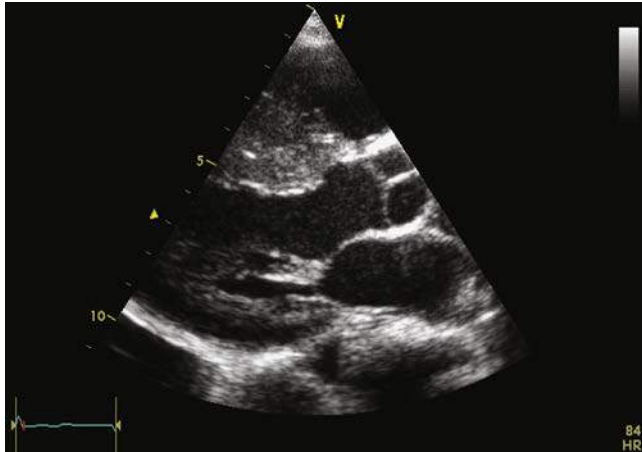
Two-dimensional (2D) echocardiogram of a patient with asymmetrical septal hypertrophy.
